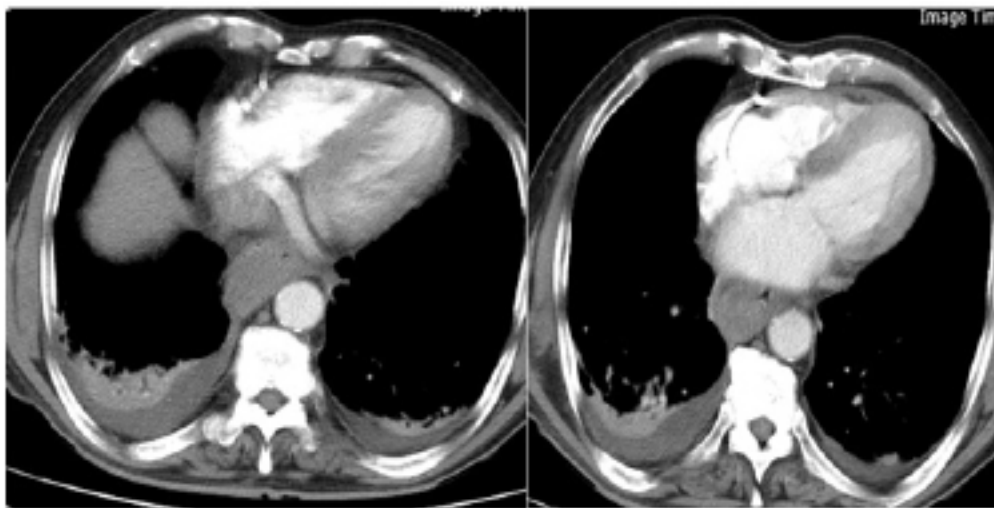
CT-scan of the chest show (IHE) middle portion of esophageal and leakage of blood to pleural space.
